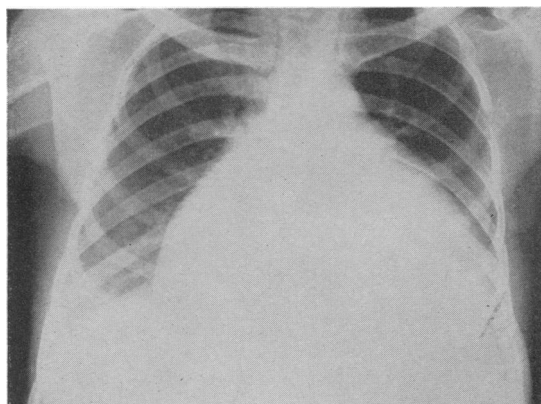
Radiograph showing a late stage of mitral incompetence and pulmonary hypertension when tricuspid incompetence has supervened. Right auricle is large; peripheral vascular markings are diminished.
